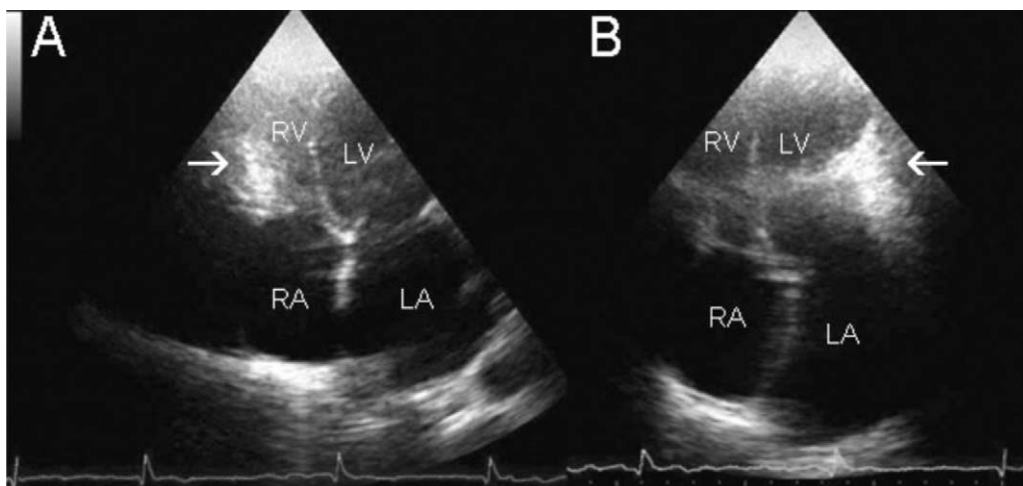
Transthoracic echocardiography: four-chamber view showing pericardial hyperechogenicity (white arrows) at the mid portion of the right (A) and left (B) ventricular walls. RA: right atrium; RV: right ventricle; LA: left atrium; LV: left ventricle.
